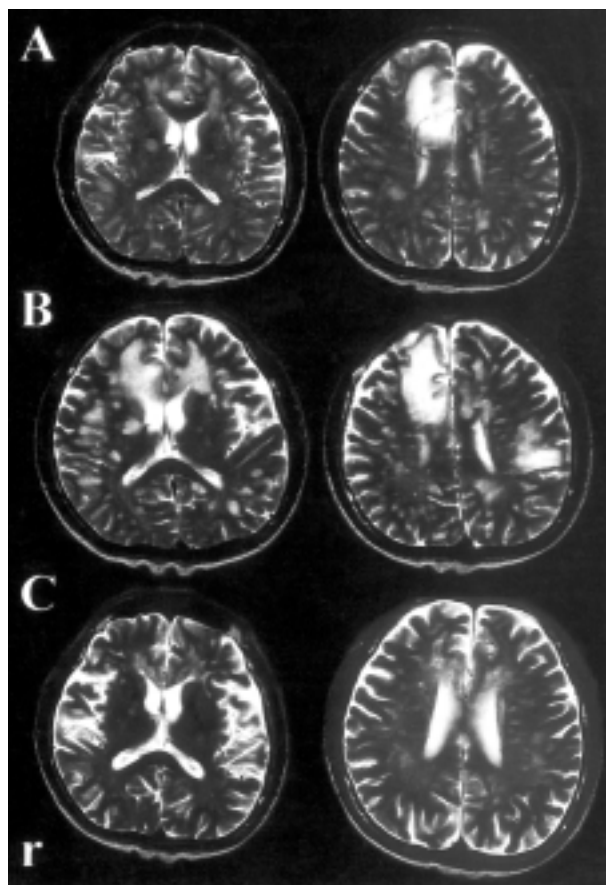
Serial brain MRI on T2-weighted images in patient 1, with multifocal demyelinating leukoencephalopathy after levamisole therapy. (A) Initial brain MRI on April 22, 2003 revealed a high signal intensity lesion in the right frontal lobe and multifocal subcortical white matter lesions in the bilateral hemispheres. (B) The follow-up brain MRI on May 8 demonstrated a deterioration of the multifocal subcortical white matter lesions. (C) The repeated brain MRI on July 12 showed an improvement with a decrease in size and number of the bilateral cerebral white matter lesions.
